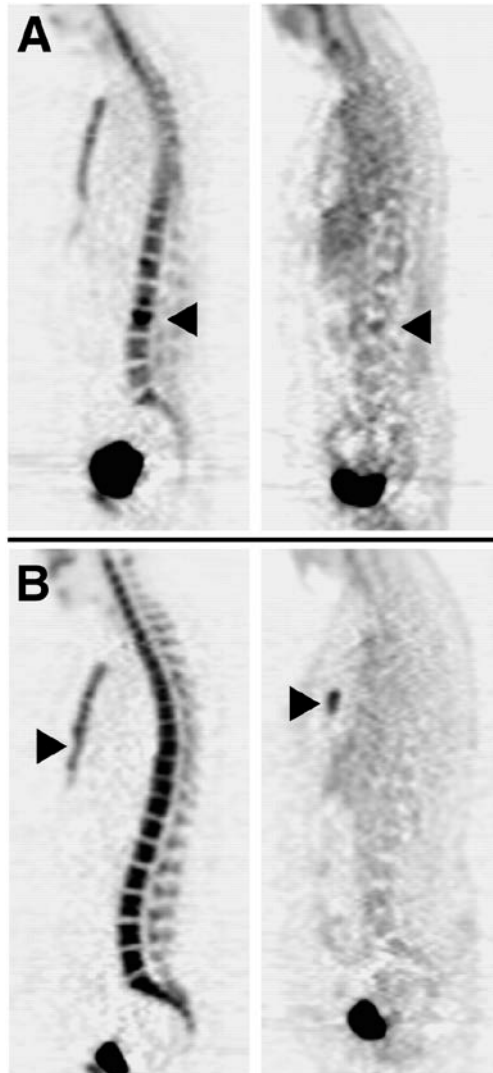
Whole-body PET imaging of two patients with bone-dominant metastatic breast cancer. (A) Patient with a sclerotic lumbar vertebral body metastasis (arrowheads) visible on sagittal ^{18}F -fluoride (left panel) and ^{18}F -FDG (right panel) PET images. (B) Patient with a lytic sternal metastasis (arrowheads) identified as a photopenic region on ^{18}F -fluoride (left panel) and enhanced uptake region on ^{18}F -FDG (right panel) PET images. Reprinted with permission from Doot RK et al, J Nucl Med. 2010;51:521-527. © by the Society of Nuclear Medicine and Molecular Imaging, Inc. <http://jnm.snmjournals.org/content/51/4/521.long>
